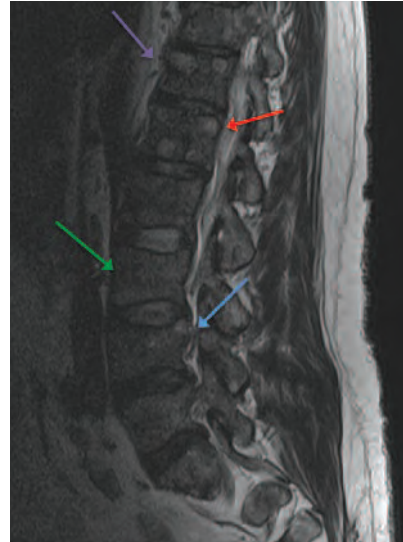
Sagittal T1-weighted MRI with contrast of the lumbar spine, showing diffuse metastatic disease of the lumbar and thoracic spine. The most marked fractures include: anterior wedge compression fracture at L1 (red arrow) with marrow oedema and visible metastases; compression fracture at L3 with marrow oedema (green arrow); and, acute-appearing compression fracture at L4 (blue arrow). Visible metastases enhancing with contrast can be seen at T12 (purple arrow).
